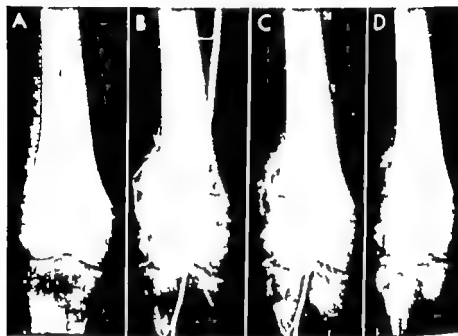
Osteogenic sarcoma of distal femur: *A*, plain x-ray showing osteolytic destruction of distal femoral condyle with small amount of new bone formation and soft tissue mass; *B*, arterial phase of femoral arteriogram. Vessel leading to area of neoplasm types tortuous, increased in number and remained of the same caliber over some distance; *C*, capillary phase. Moderate amount of pooling of contrast medium within tumor. Evidence of arteriovenous shunt is shown in equalization of contrast in proximal neoplasm (arrow, upper right); distal vein still empty of contrast medium; *D*, venous phase. Only slight residual pooling. (Courtesy of Schobinger R. *et al.* Cancer 11:215-220, May, Apr. 1958.)
